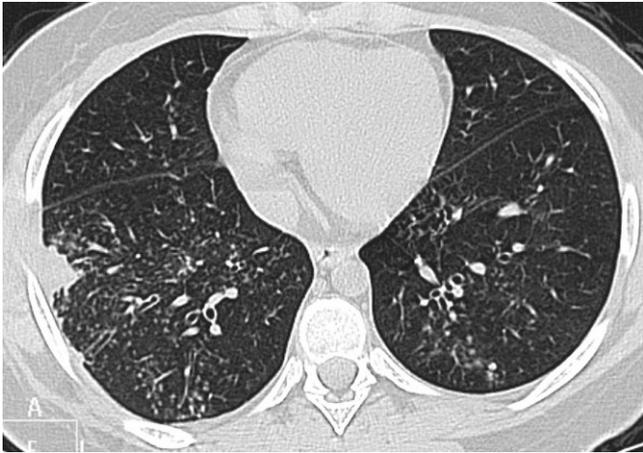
A 15-year-old girl with mild respiratory symptoms and a confirmed diagnosis of H1N1. A computed tomography scan performed at the carina level shows centrilobular nodules and a tree-in-bud pattern heterogeneously distributed through the lungs, as well as a pleural-based consolidation in the right lower lobe. The girl recovered without the need for admission to the Intensive Care Unit.
